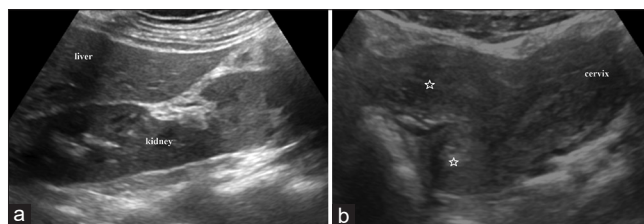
Transabdominal ultrasound images of the right lumbar region (a) and the pelvis (b) showing two uterine cavities (star) with single cervix (b). There is absence of kidney in left renal fossa. The left kidney was seen in the right renal fossa and fused with the right kidney (a)
